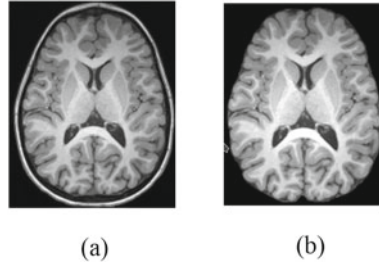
Results of skull stripping for patient-specific preoperative MRI. a Preoperative MRI image, b Skull-stripped MRI
